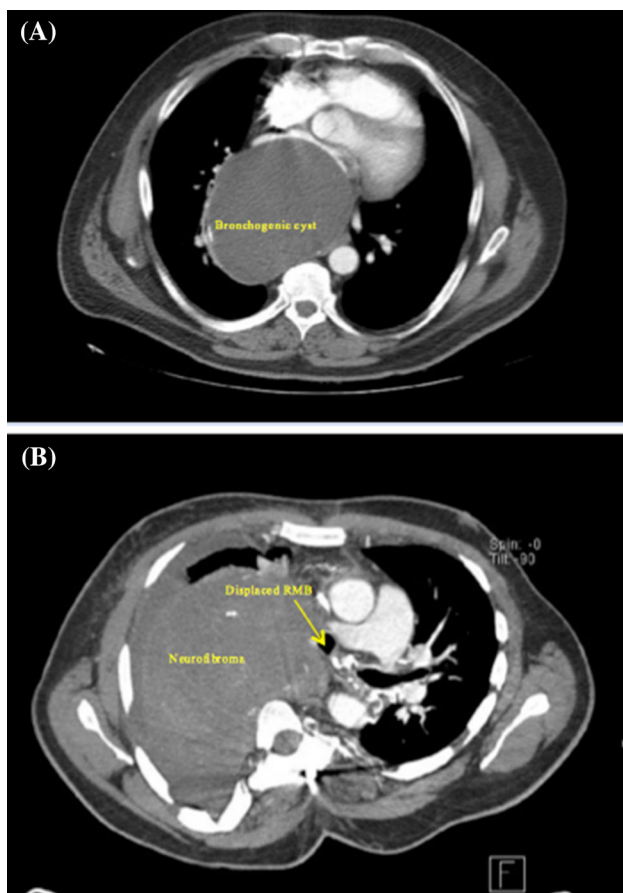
(A) Transverse section of preoperative non-contrast CT of patient with large bronchogenic cyst (maximum diameter 13 cm) without significant airway compression. (B) Transverse section of contrast-enhanced CT of patient with atypical neurofibroma (maximum diameter 16 cm) causing compression of SVC, trachea, and right bronchial tree, with right-sided pleural effusion and compression atelectasis. CT = computed tomography; SVC = superior vena cava; RMB = right main bronchus
